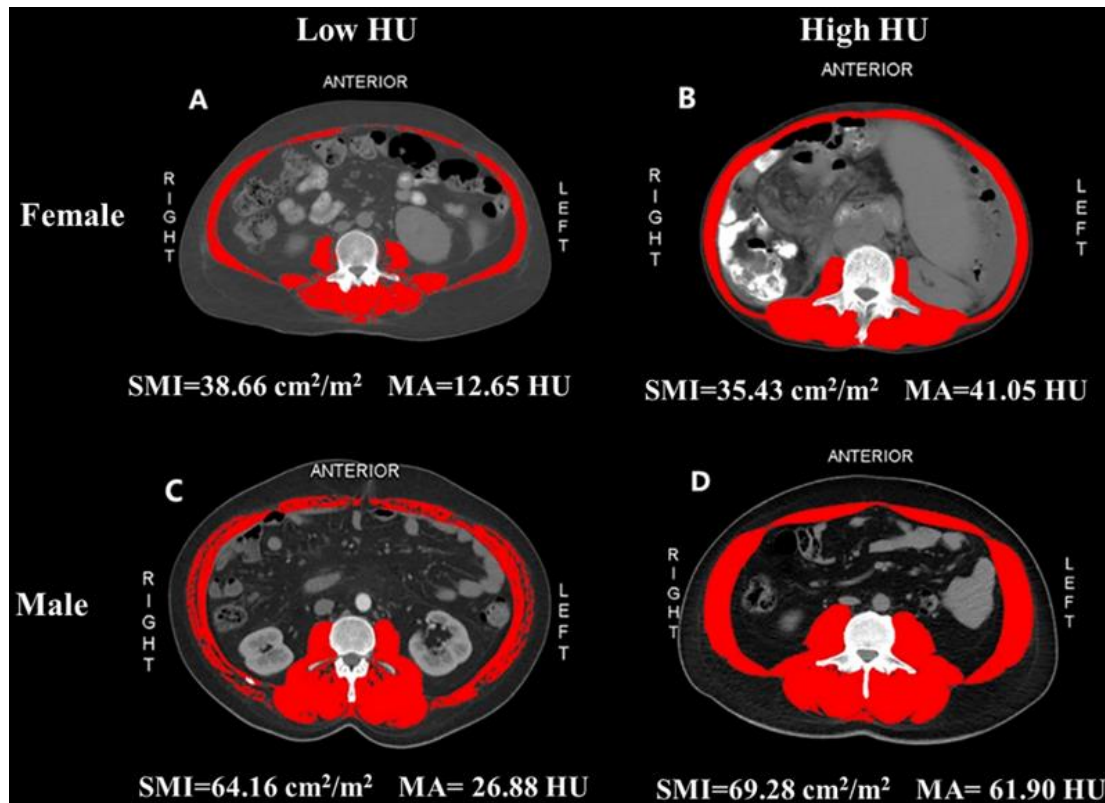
Comparison of two female (A, B) and two male (C, D) patients with cirrhosis. Abdominal CT images taken at the third lumbar vertebra. The red shadows show the skeletal muscle areas from -29 to +150 HU. Images A and B, images C and D have similar skeletal muscle index (SMI) values, but the muscle attenuation (MA) values are obviously different.
